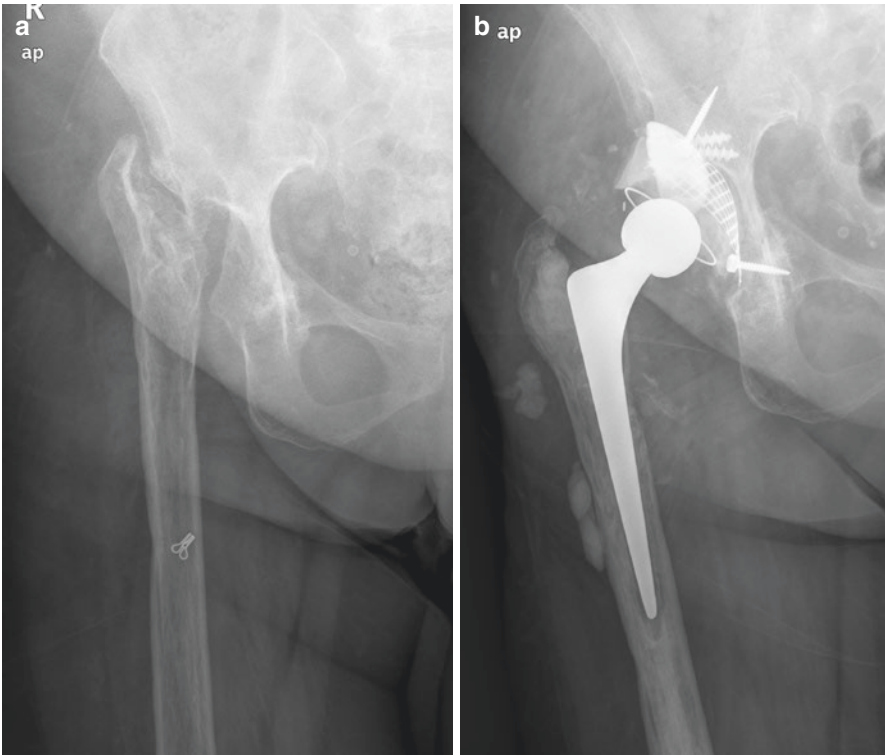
(a) Anteroposterior radiograph of the pelvis of a 83 year-old woman shows a resection-arthroplasty done 28 years earlier due to infection of a total hip arthroplasty. (b) The hip was reconstructed using a tantalum augment associated to bone impacting grafting technique with a cemented cup and bone impacting technique in the femur
